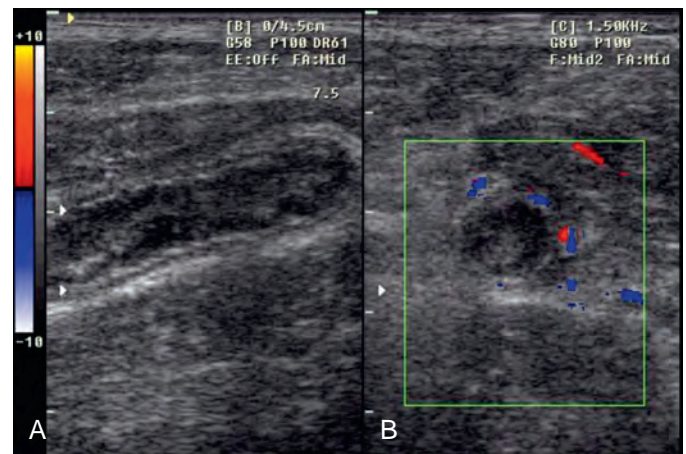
Appendicitis: sonographic features. A. A dilated, inflamed appendix is visualized along its long axis on this sonogram of the right lower quadrant. B. The inflamed appendix, imaged along its transverse axis, shows mural thickening and increased color Doppler flow to the appendiceal wall, attesting to the hyperemia accompanying the inflammation.
